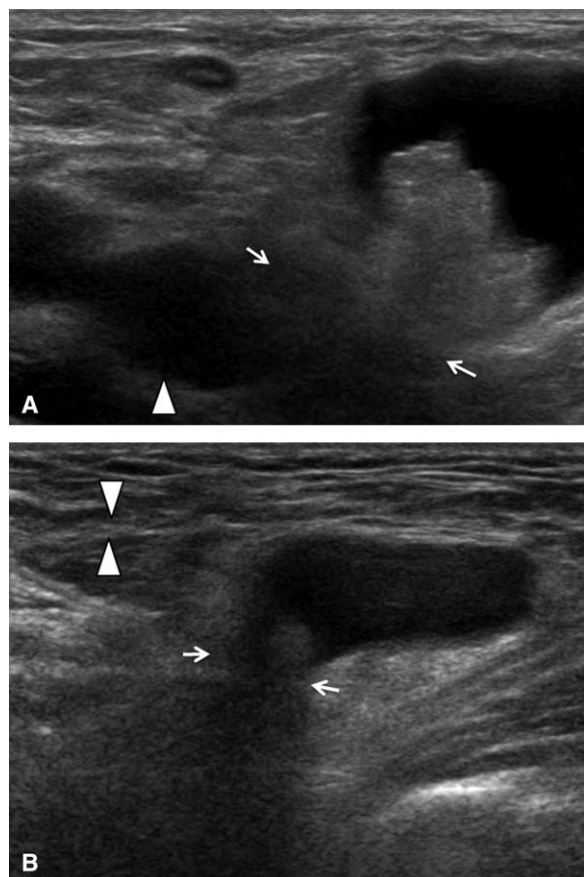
(A) Transverse sonogram of a right groin shows a femoral hernia. The neck (arrows) of the hernia is arising from the femoral canal medial to the femoral vein (arrowhead). Mild medial indentation of the femoral vein is present. (B) Longitudinal sonogram from the same patient shows the neck (arrows) of the femoral hernia arising inferior to the inguinal ligament (arrowheads).
